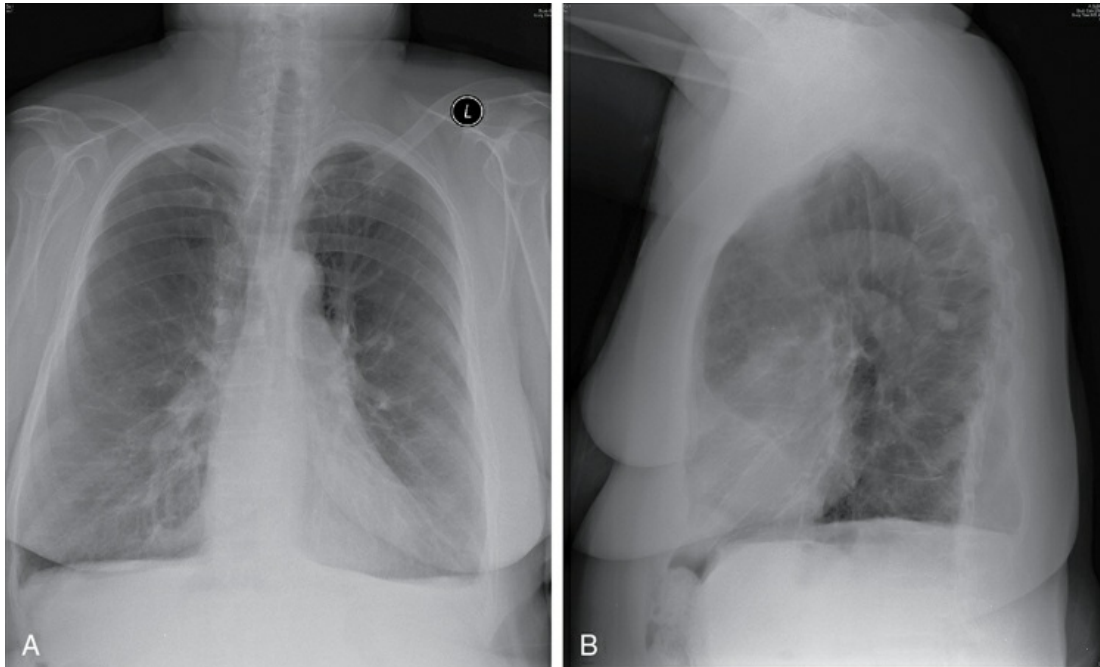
Chest radiographs of a patient with severe chronic obstructive pulmonary disease. The lungs are hyperinflated and the diaphragms are low and flat. A, Posteroanterior view. B, Lateral view.
